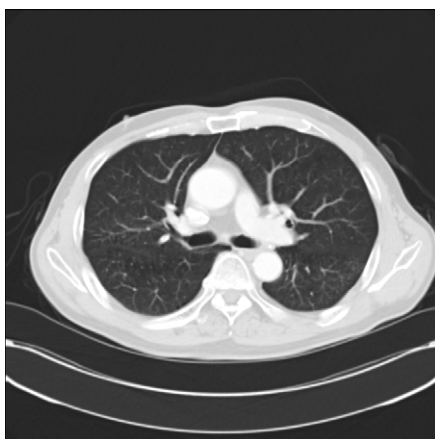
Chest CT showed total remission of tumor at left hilum at Oc. 2010
